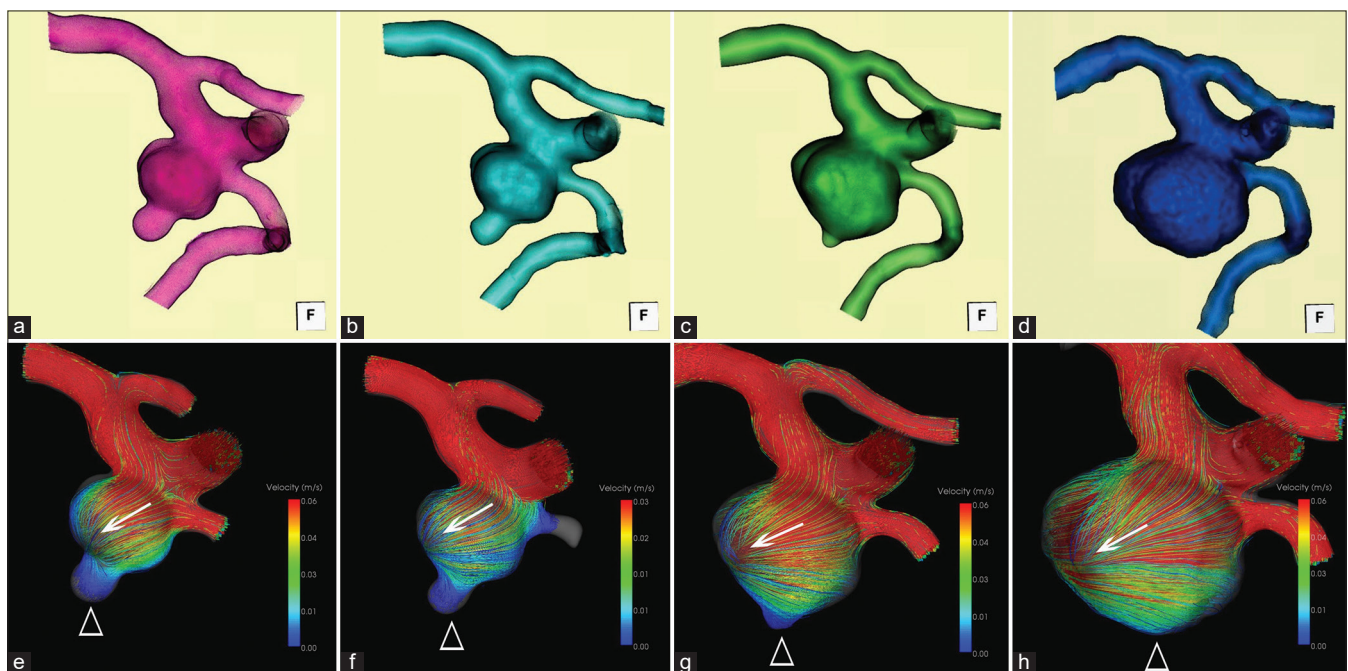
Seven-year follow-up of 3D-CTA and hemodynamics of the right unruptured IC-PC aneurysm. The morphology of the bleb and dome was sequentially reconstructed using 3D-CTA obtained (a) at the 1st year, (b) 2nd year, (c) 5th year, and (d) 7th year, projected from similar view directions. Hemodynamics (streamline and WSS) of the aneurysm were sequentially analyzed (e) at the 1st year, (f) 2nd year, (g) 5th year, and (h) 7th year. Arrows indicate the axis of the streamline, and empty arrowheads indicate the location of the bleb.
